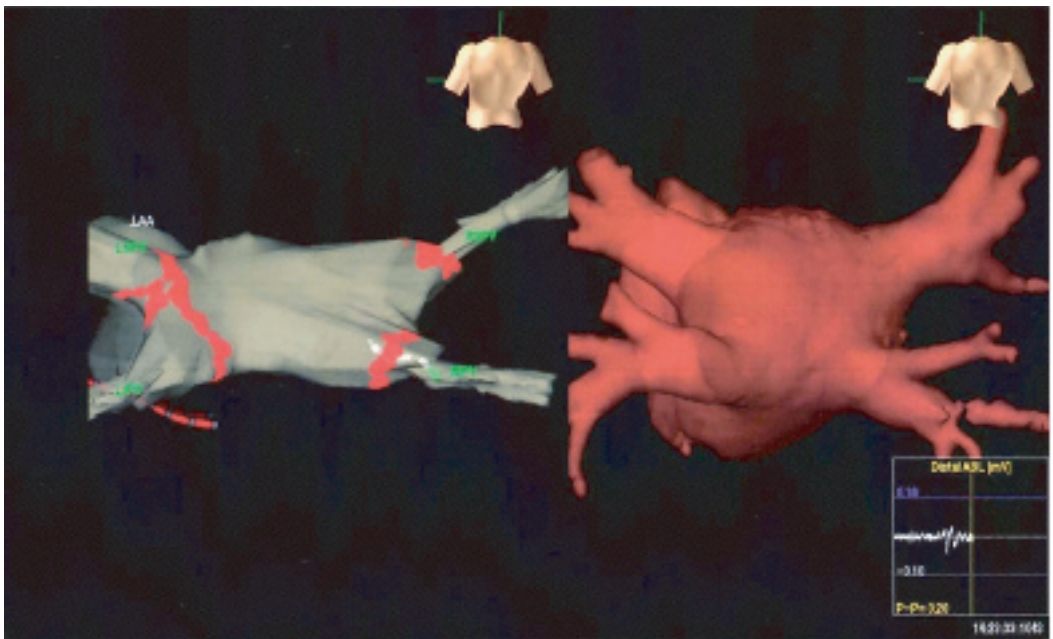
Electroanatomical mapping of the left atrium (left panel) and CT angiography of the left atrium and pulmonary veins on the right. Images were integrated during the ablation procedure. See the Videoclip 41.X. Courtesy of Jeffrey Olgin, UCSF.
